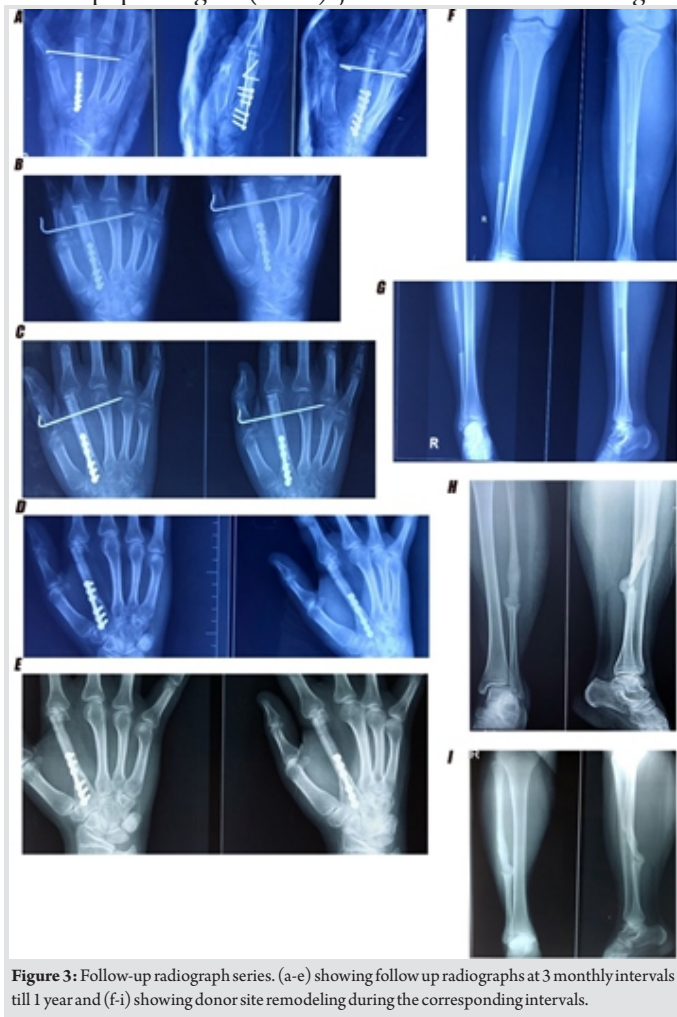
Follow-up radiograph series. (a-e) showing follow up radiographs at 3 monthly intervals till 1 year and (f-i) showing donor site remodeling during the corresponding intervals.
